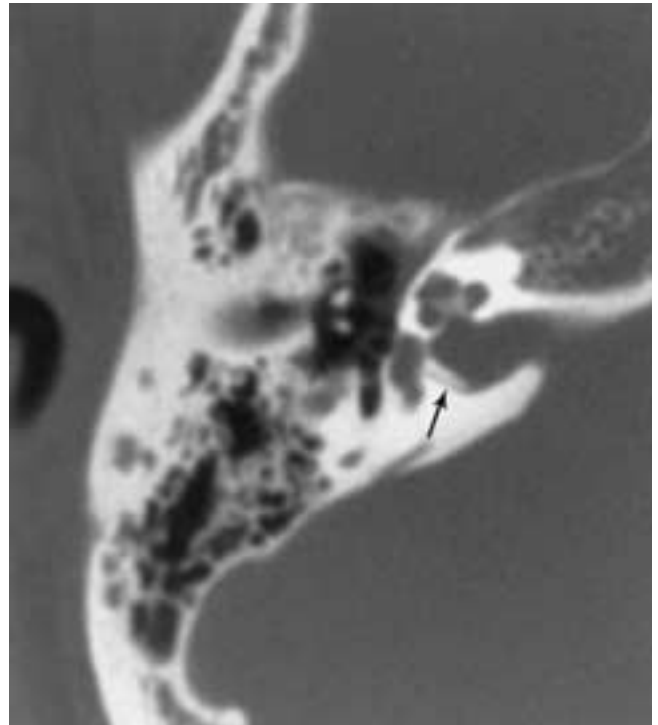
Pseudofracture, singular canal. Magnified axial CT image obtained through the IAC demonstrates a tiny channel parallel and posterior to the IAC fundus (*arrow*). (From Swartz JD, Harnsberger HR. Imaging of the Temporal Bone, 3rd ed. New York: Thieme, 1998.)
